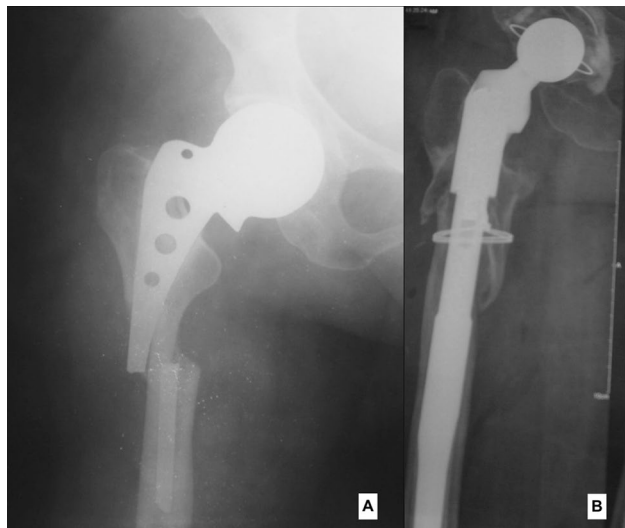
A and B Radiograph showing periprosthetic femoral fracture with fracture of Austin Moore Prosthesis (A). Revision surgery was performed with a modular stem (B)
